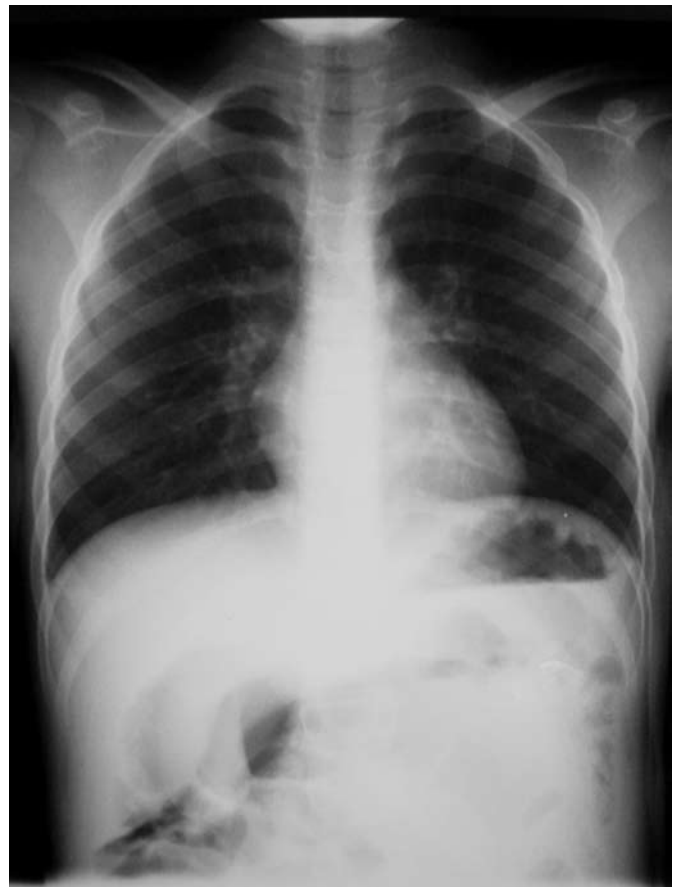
Erect chest radiograph indicating dilated loops of small bowel extending infradiaphragmatically on the left where the spleen is normally located.
